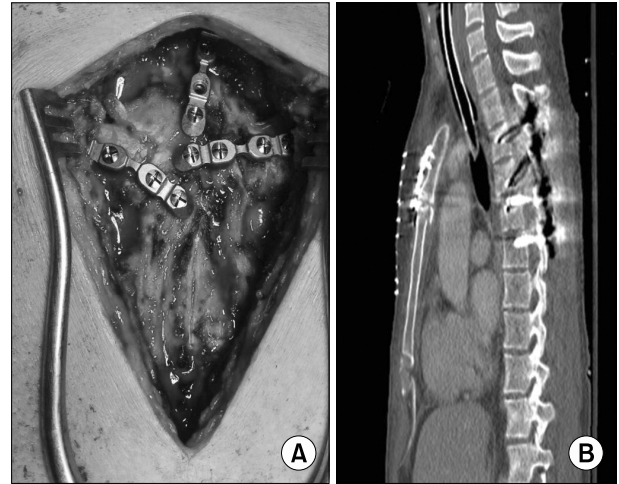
(A) After the successful reduction, the sternum was rigidly fixed with three 4-holed SternaLock straight-plates. (B) A post-operative computed tomography scan shows reduction and rigid fixation of the fractured sternum.
